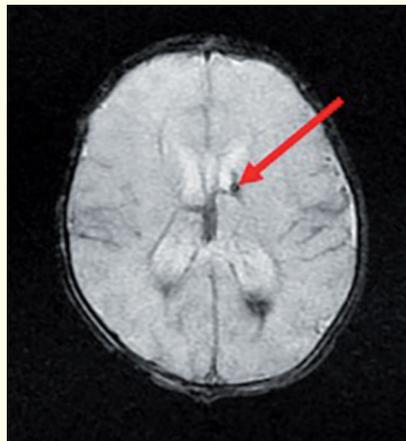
MRI scan of subependymal bleeding, GRE sequence.
